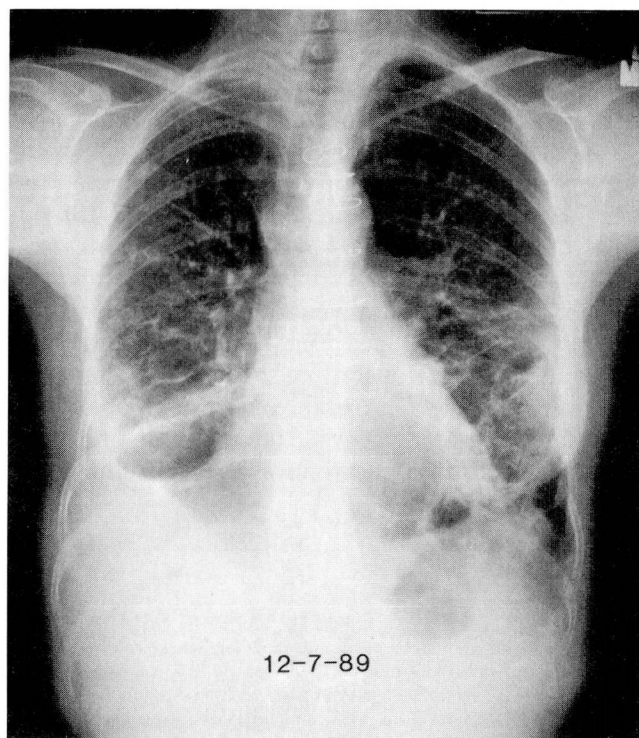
Chest radiograph 8 months after single-stage bilateral lower-lobe bullectomy via sternotomy revealing expansion of the upper lobes and interstitial infiltrates of sarcoidosis.
